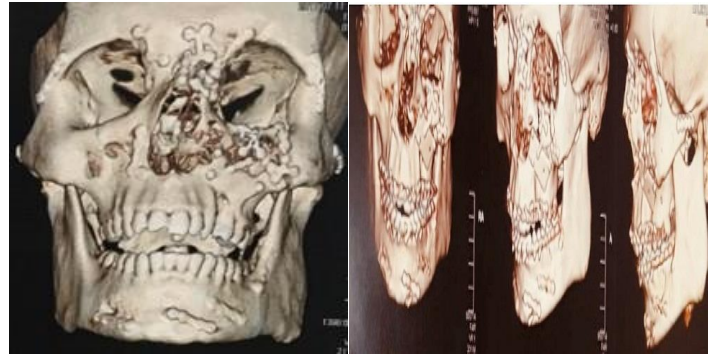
CT scan of patient after surgery
